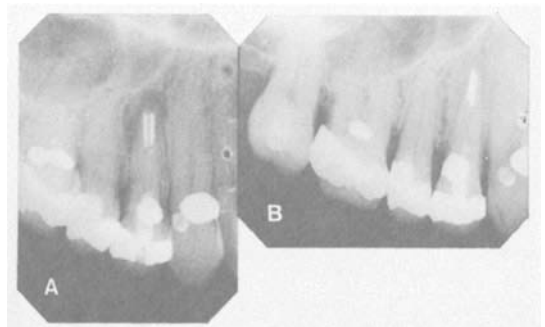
(A) Radiograph of 4| immediately following root canal sealing with apical silver tips and AH 26 sealer. (B) The same tooth six months later, showing resolution of the periapical lesion. The canals were used subsequently for retention of a post-retained crown.
